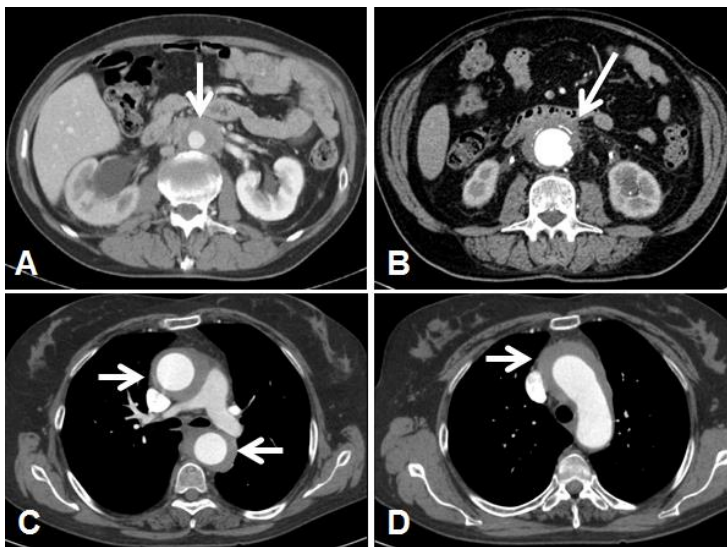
CT findings in periaortitis. The images show the CT appearance of periaortitis with typical localization (A), where the soft-tissue mass (arrow) surrounds the anterior and lateral sides of the abdominal aorta, spreads to the right ureter and causes hydronephrosis. CT appearance of peri-aneurysmal periaortitis (B): the fibro-inflammatory tissue encircles a dilated abdominal aorta (arrow). CT appearance of thoracic periaortitis (C, D). The perivascular tissue surrounds the ascending thoracic aorta (C, upper arrow), the aortic arch (D, arrow) and the descending thoracic aorta (C, lower arrow).
